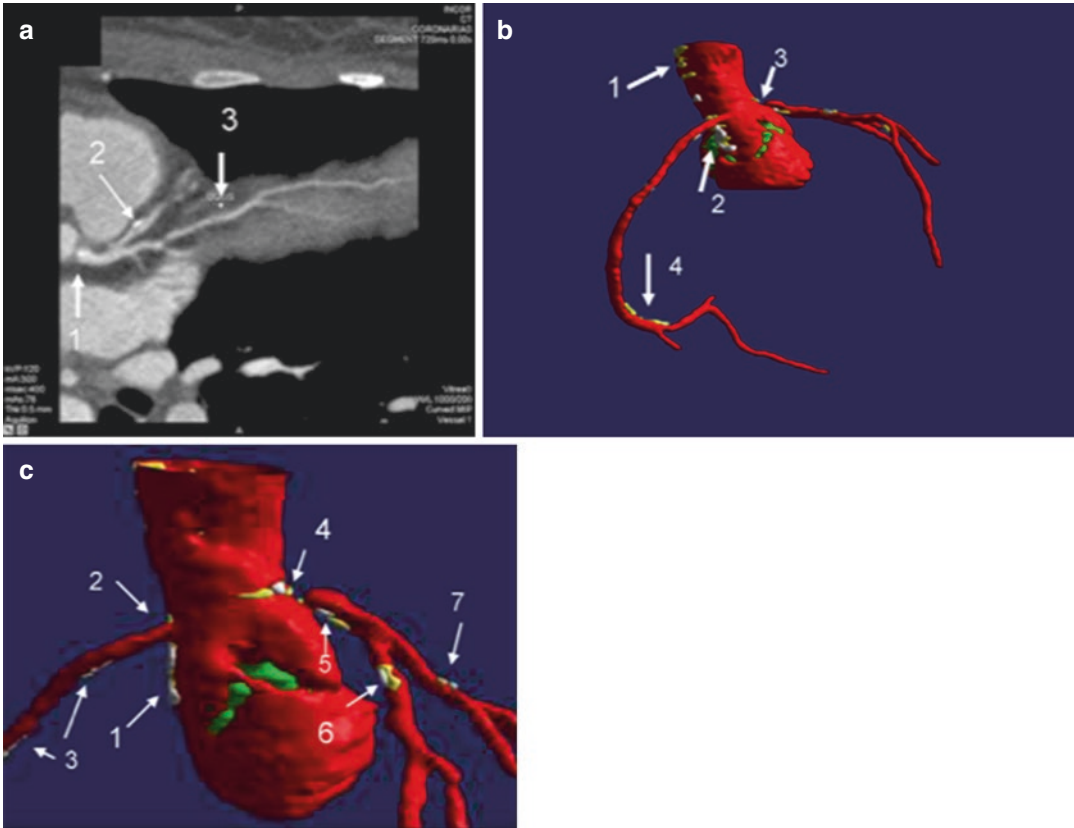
Subclinical coronary atherosclerosis detected by cardiac-computed tomography in angiography in HoFH patients. An oblique coronal view in 2D multiplanar reformatted image. Mixed atherosclerotic plaques compromising the origin of the left main coronary artery (arrow #1), left anterior descending artery (arrow #2), and left ramus artery (arrow #3) are shown. (b) Anterior view of a three-dimensional model built from 2D images, using segmentation based on Hounsfield units. Non-calcified plaque in yellow (arrow #1) and calcified plaques in white compromising ascending aorta, right coronary artery ostium (arrow #2) and proximal left main artery (arrow #3) can be seen in this view. Arrow 4 depicts mixed
